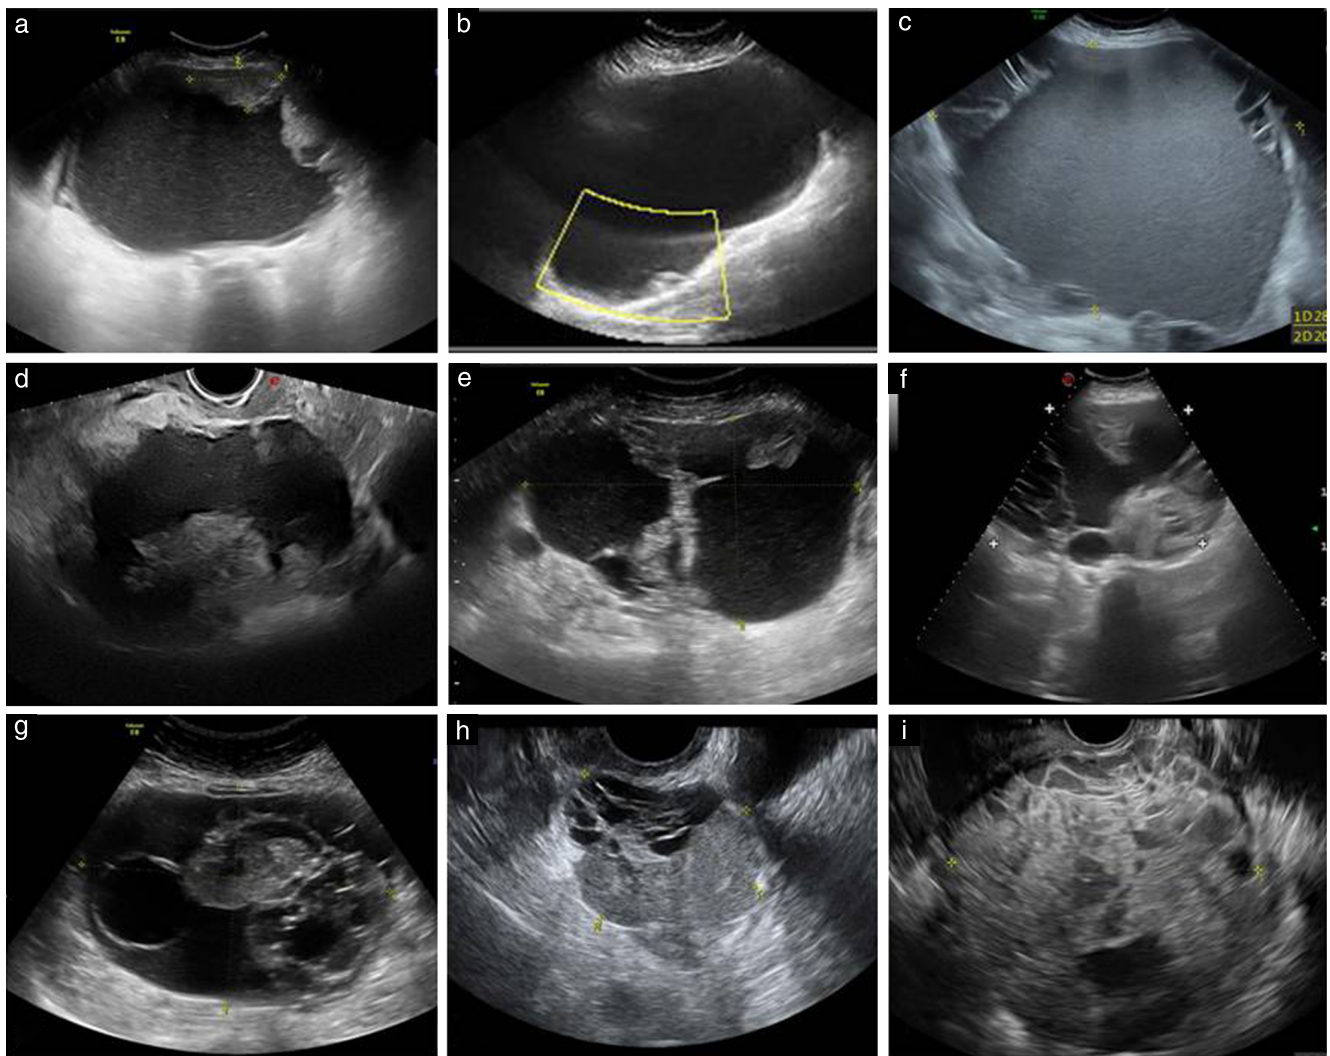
Ultrasound images of gastrointestinal-type invasive mucinous carcinomas, presenting as unilocular-solid (a,b), multilocular (c), multilocular-solid (d–g) or solid (h,i) cysts, the majority being multilocular-solid cysts with > 10 locules (f,g), rather than 2–10 locules (d,e). Lesions in (a,c–e,g–i) were diagnosed correctly by ultrasound examiner as invasive, mass in (f) was misdiagnosed as borderline and mass in (b) was misdiagnosed as benign.
